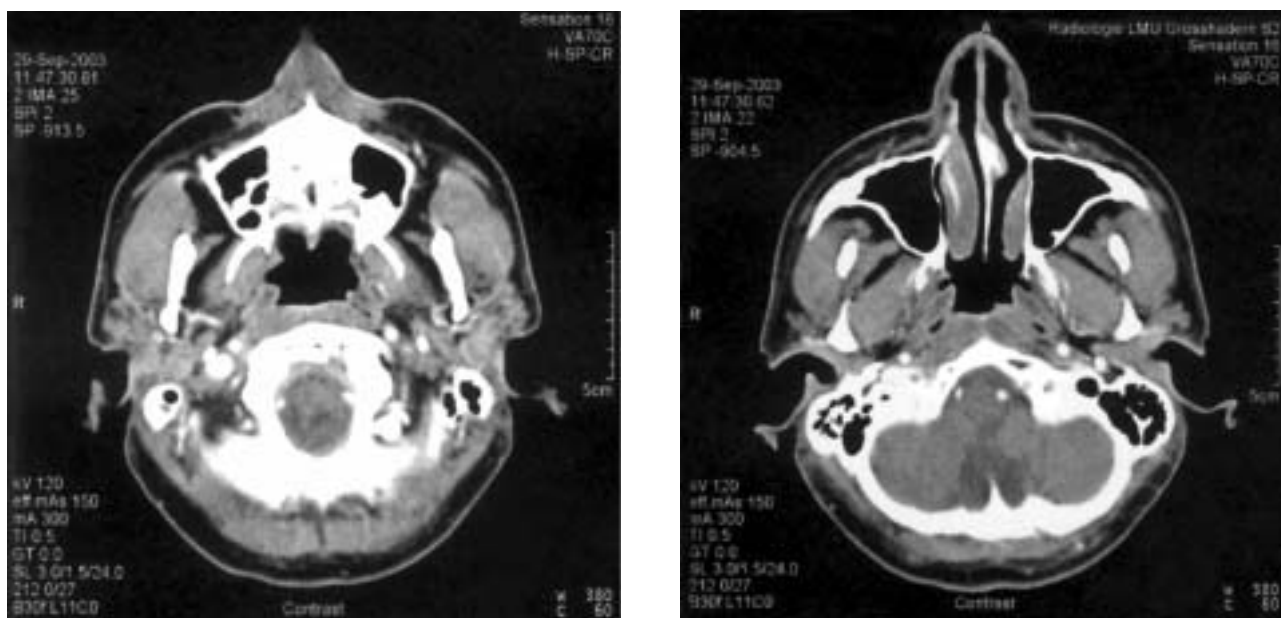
(A, B) Four weeks after the beginning of the treatment, CT scans revealed a complete regression of the mass.
